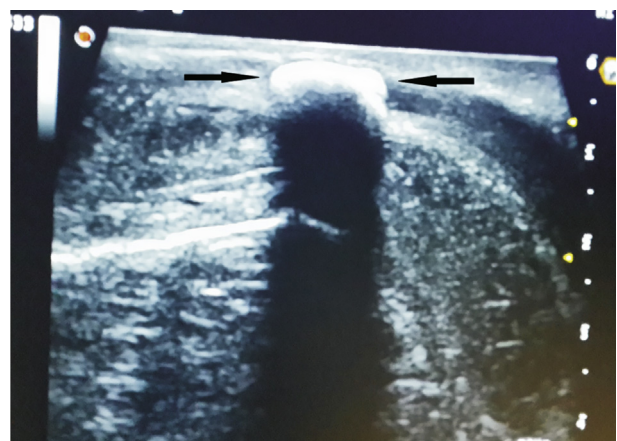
Bedside ultrasound image of the calculus (arrow).
